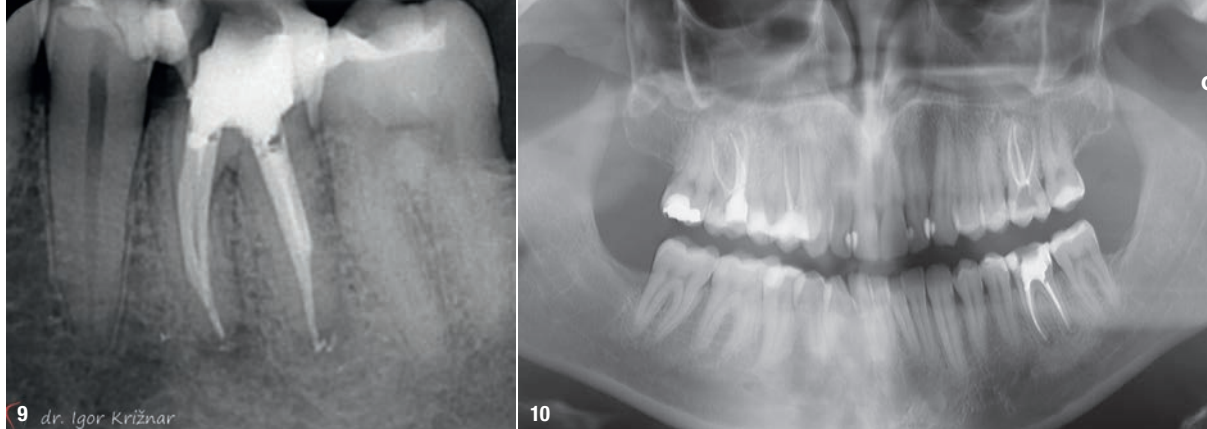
Radiograph of tooth #36 three months after the clinical crown lengthening and endodontic treatment. Fig. 10: Panoramic radiograph three months after the treatment.
